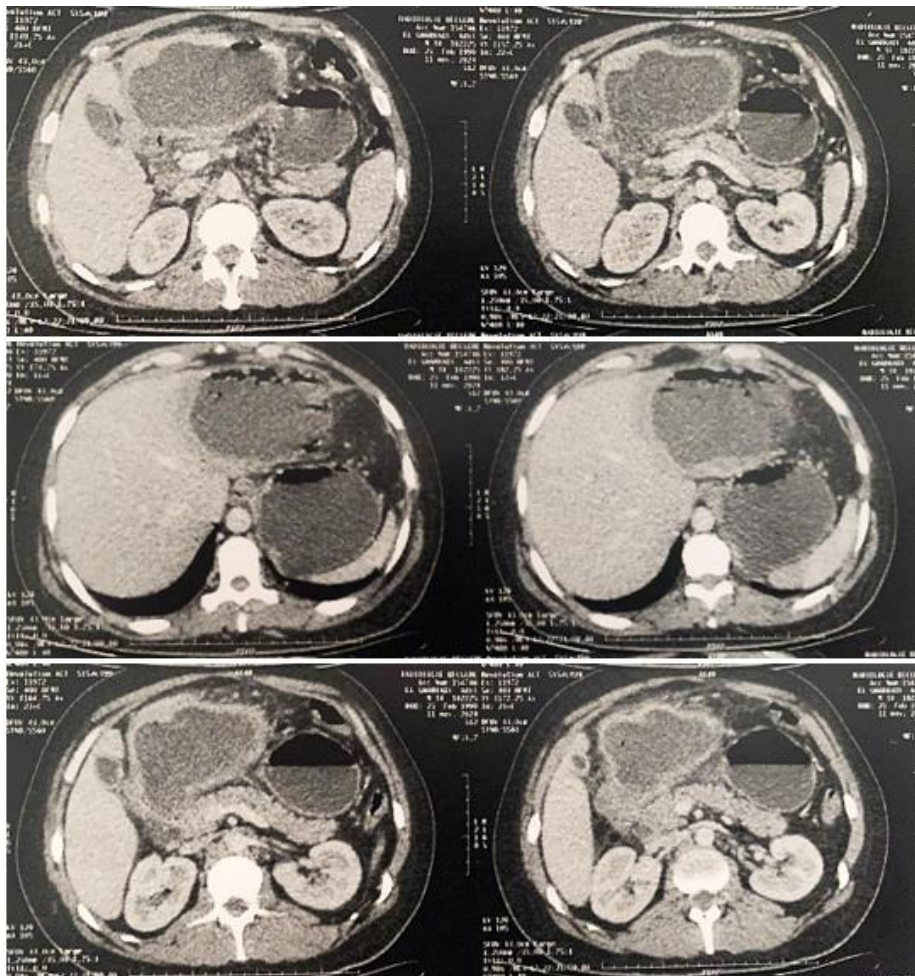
CT scan axial view showing large superinfected cystic lesion of the left hepatic lobe, fistulised into the intrahepatic bile ducts (with aerobilia) and into the duodenal bulb, with marked thinning of its inner wall and peritoneal bulging, without intra-peritoneal collection or free fluid. Pre-rupture stage.
